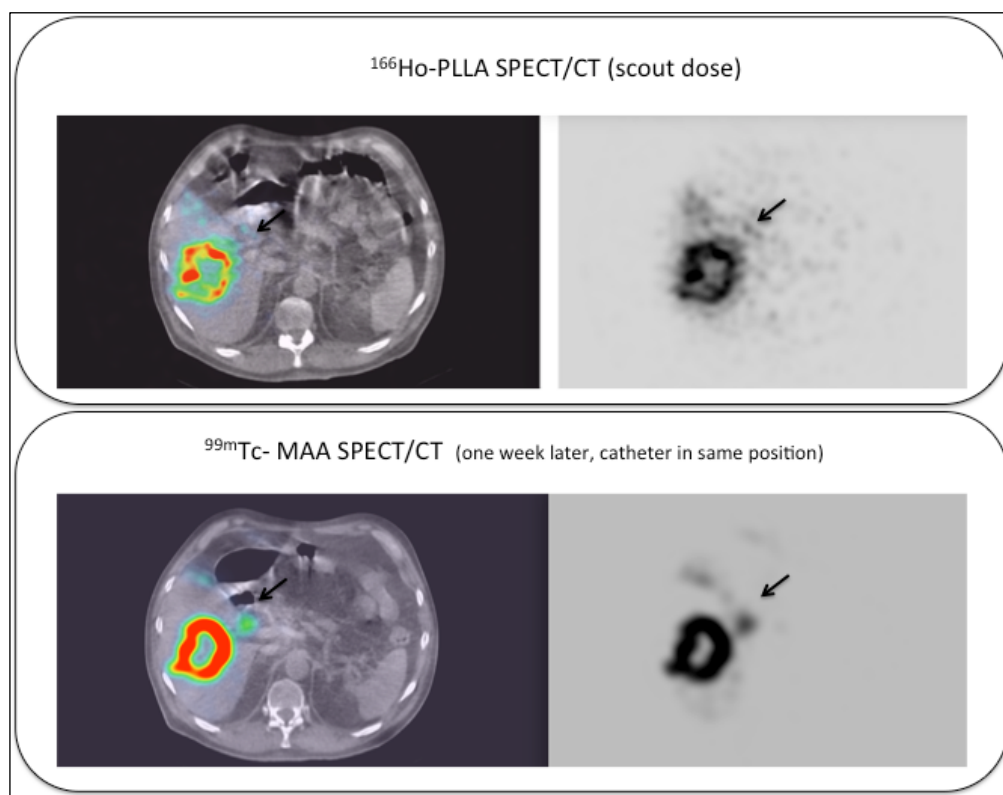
^{166}Ho SPECT/CT scout dose and $^{99\text{m}}\text{Tc}$ MAA SPECT/CT in the same patient (unpublished data). A duodenal uptake (black arrow) was well defined with MAA imaging but hardly visible with ^{166}Ho SPECT/CT due to the lower spatial resolution.
